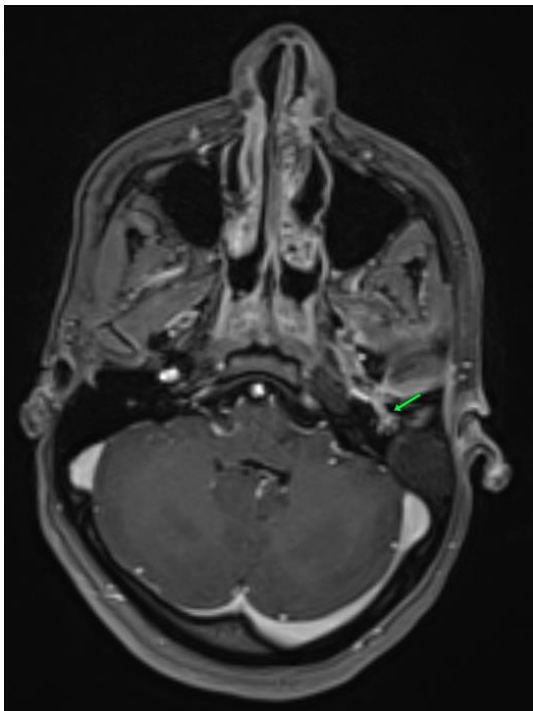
Axial T1 post-contrast MRI revealing saccular outpouching of the left internal carotid artery consistent with pseudoaneurysm.
